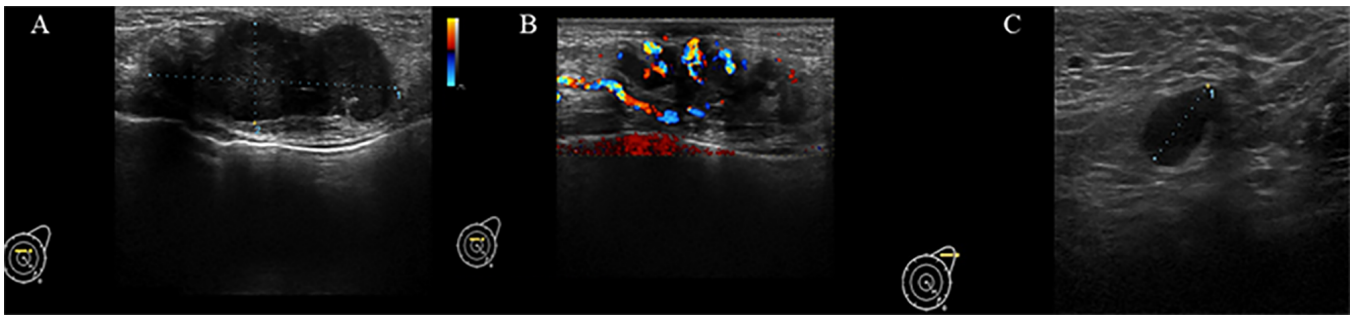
Ultrasonography images of the patient. (A) Preoperative ultrasonography image showing a solid hypoechoic mass with a measurement of ~39x14 mm in the glandular layer of the left breast. (B) Abundant blood flow in and around the tumor detected during Doppler examination. (C) Preoperative ultrasonography image showing tumescent lymph nodes in the left axillary fossa with a maximum size of ~10 mm.
